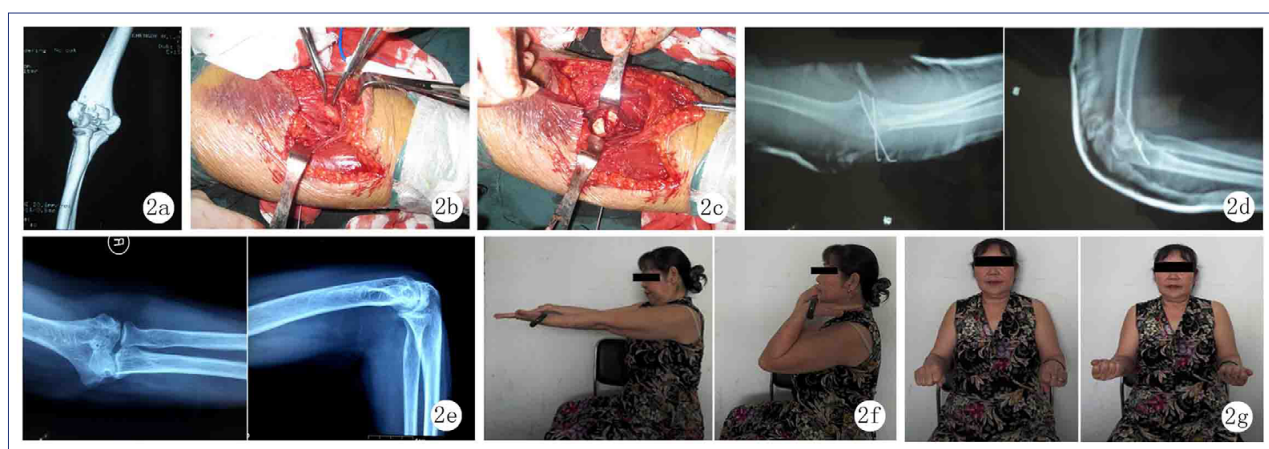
A 64-year-old female patient with coronal shear fractures of the right distal humerus a. Preoperative three-dimensional CT image; b. Exposure of brachial artery and median nerve in operation; c. Exposure of trochlea fracture fragment in operation; d. Anteroposterior and lateral X-rays 2 days after the operation; e. Anteroposterior and lateral X-rays 1 year after the operation; f. Function of the flexion and extension of the elbow 1 year after the operation; g. Function of the pronation and supination of the arm 1 year after the operation
